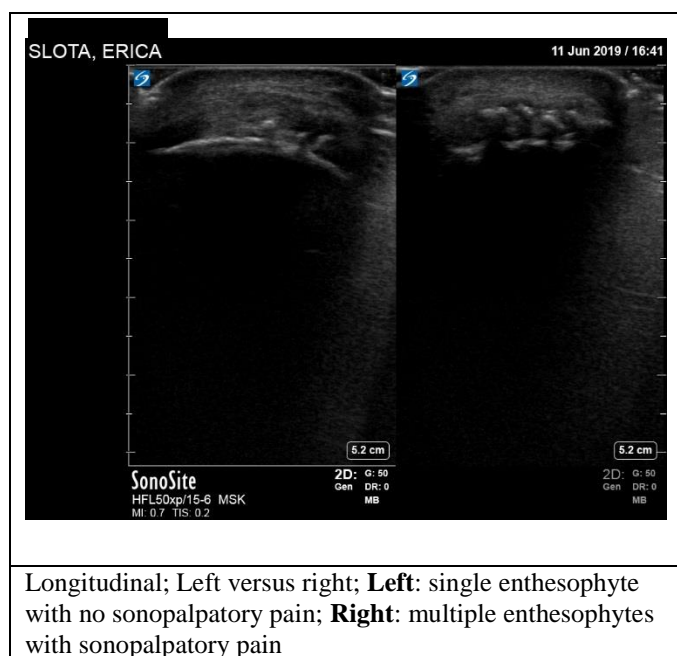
Left versus right Achilles tendon diagnostic ultrasound image
